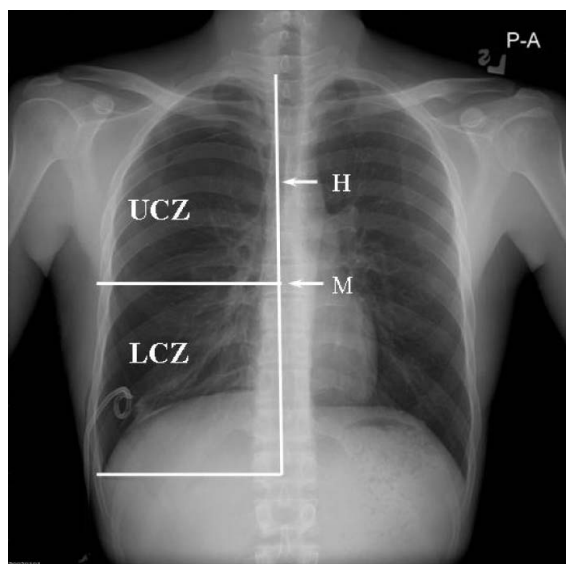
Chest radiograph shows right side pneumothorax with pigtail tube drainage in the lower chest zone. LCZ was defined as the lower half of the hemithorax. H = height of hemithorax; M = mid-point of height of hemithorax; UCZ = upper chest zone; LCZ = lower chest zone.
